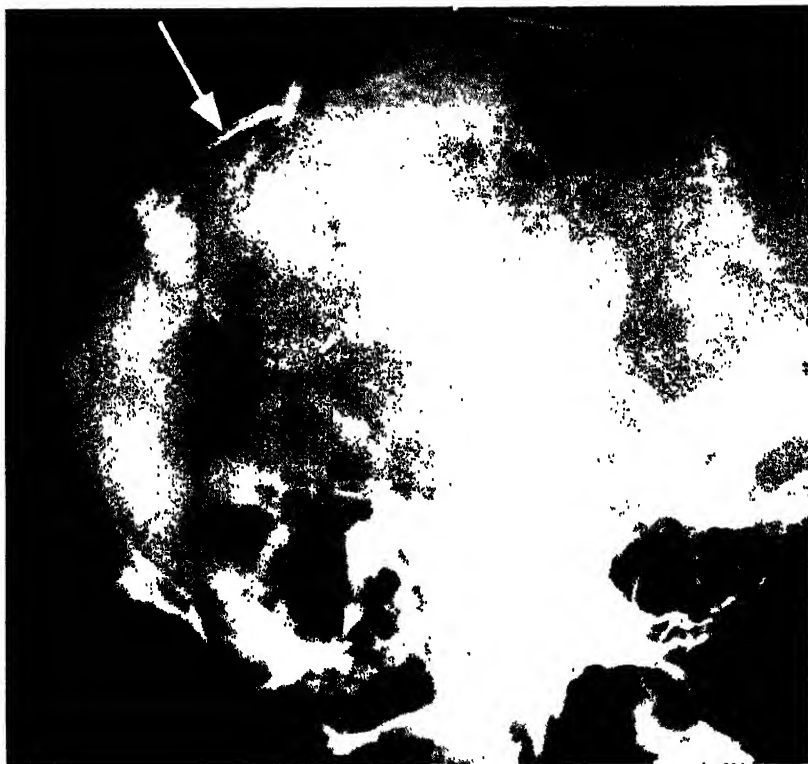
Radiograph showing a depressed fracture of the skull.
